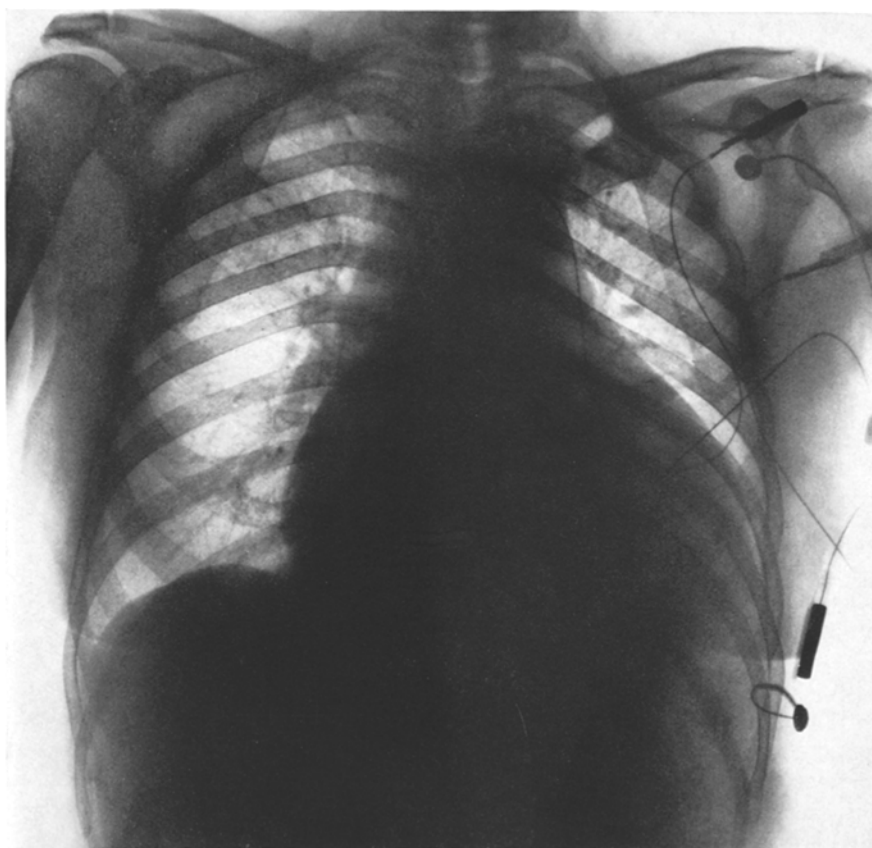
Chest-X-ray taken shortly before death
